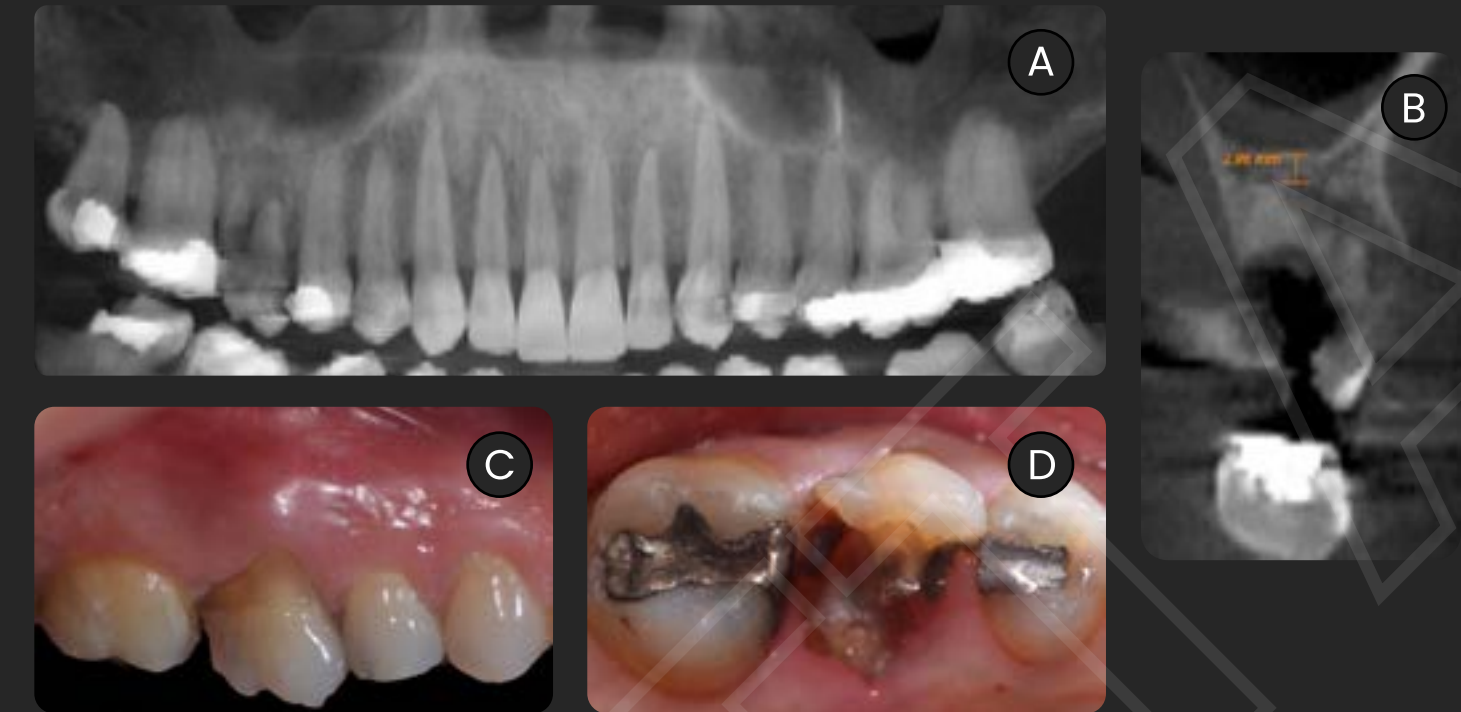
A: Panoramic radiography revealing fracture of element 16; B: CBCT image of extensive radicular & bone resorption of the region; C and D: Lateral & occlusal photos of pretreatment conditions. [This case was conducted by Dr. Marcos Motta (Rio de Janeiro, Brazil)].
